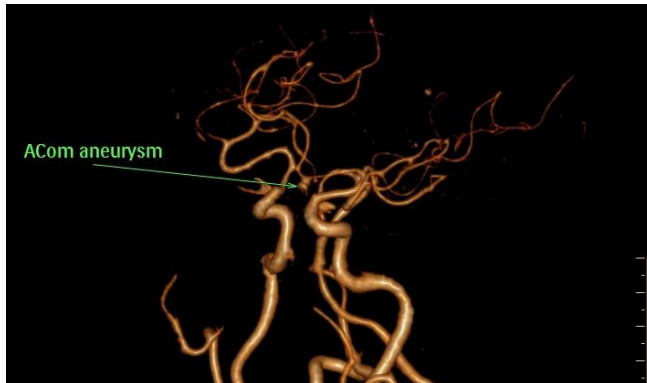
3D cerebral CTA showing a saccular aneurysm at the ACoA.
